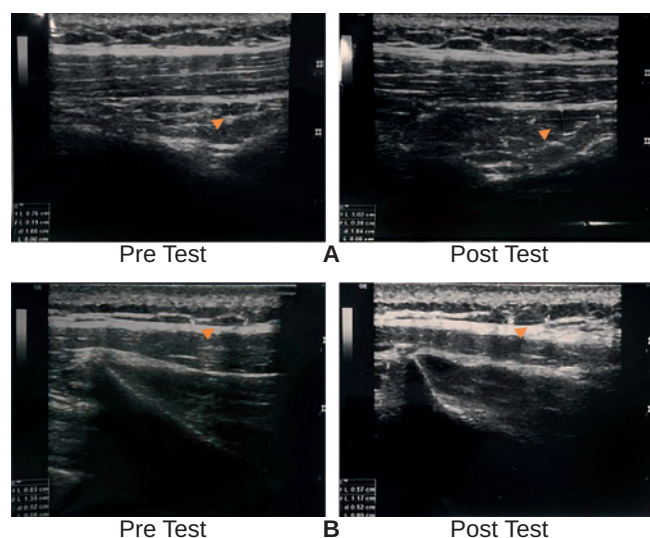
Ultrasound Images of Neck Muscles Pre- and Post-Dry Needling Showing Changes in Trigger Point Size
